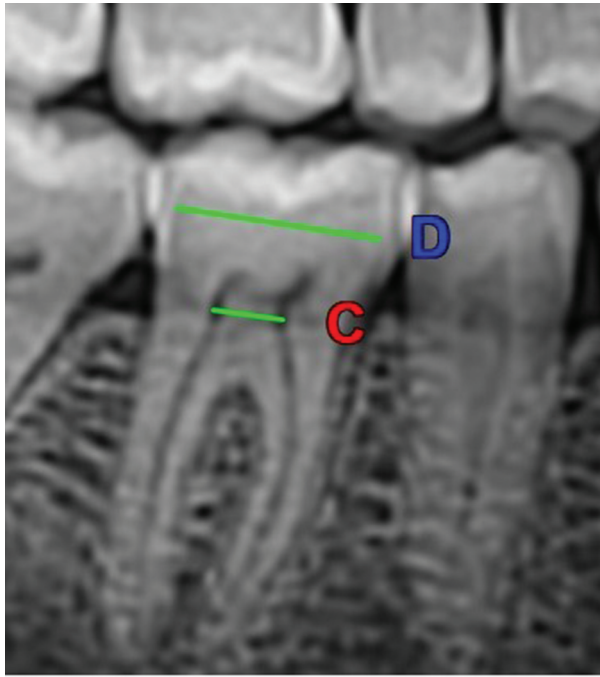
Left mandibular first molar measurements to calculate the novel model on panoramic radiography. Crown width was measured from the midline of the crown without including enamel. Pulp width was measured from the midline of the pulp chamber.
